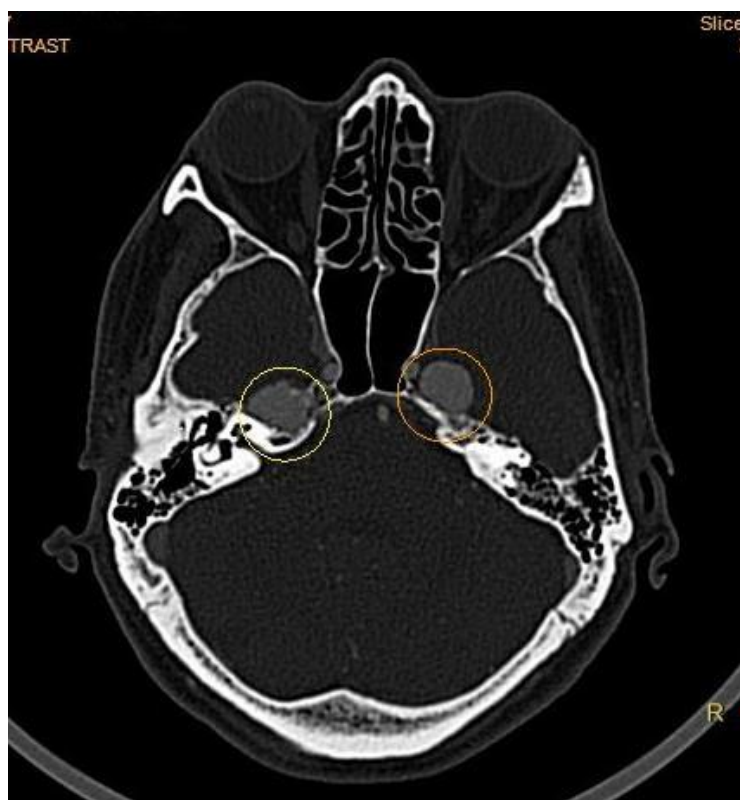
Axial post contrast CT image in a bone window setting shows bilateral aneurysms at the petrous apex
